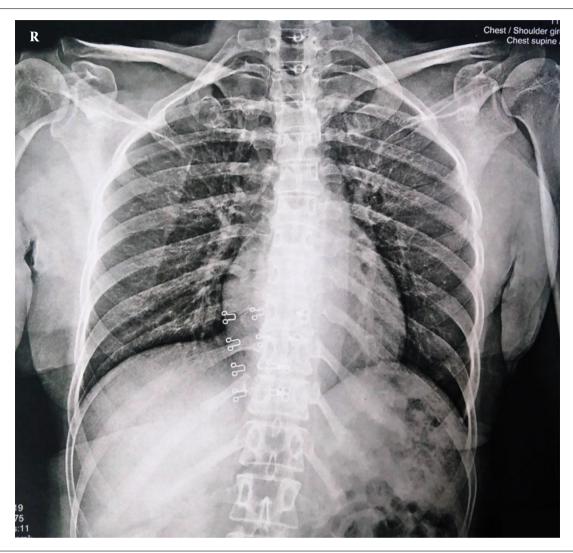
Chest X-ray of the patient. Increase in fibrosis and normal heart size.
